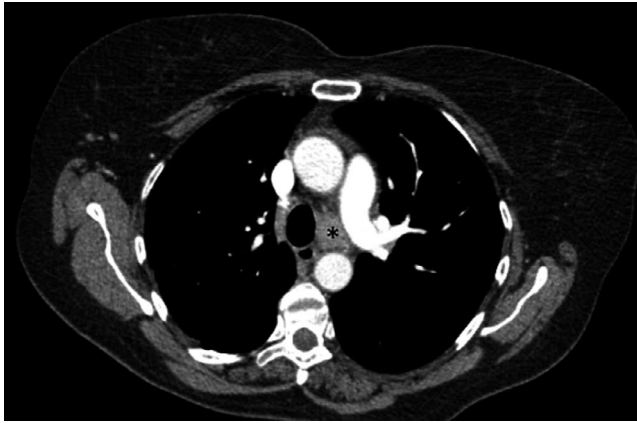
Axial contrast material-enhanced CT scan (mediastinal window) shows enlarged left para-tracheal lymphadenopathy (*)
